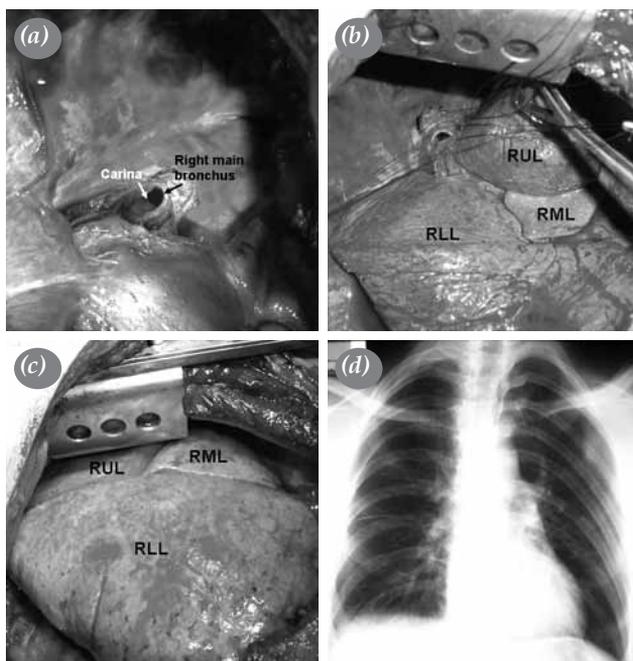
(a) A view of the complete avulsion of the right main bronchus. (b,c) Successful bronchoplastic repair and re-expansion of the right lung is shown. (d) The chest roentgenogram as seen on the postoperative tenth day. RUL: Right upper lobe; RML: Right middle lobe; RLL: Right lower lobe.
